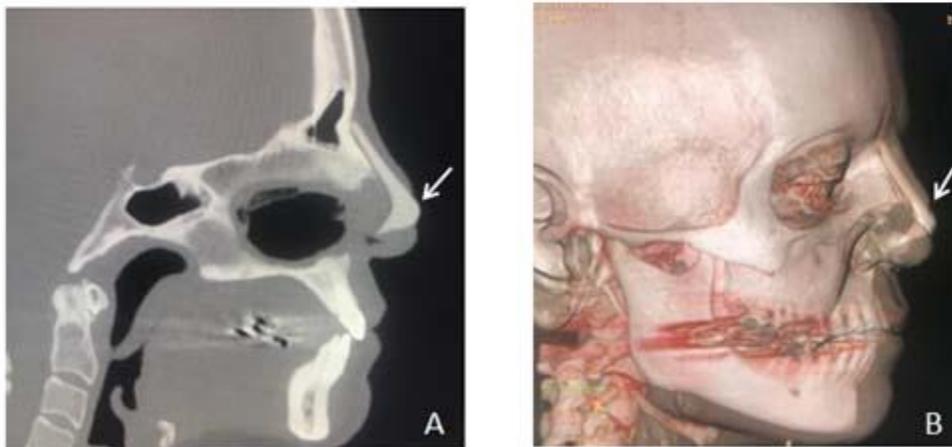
A - CT sagittal reformatation and B - 3D volumetric rendering showing silicone nasal implant complication with extrusion (white arrows)
